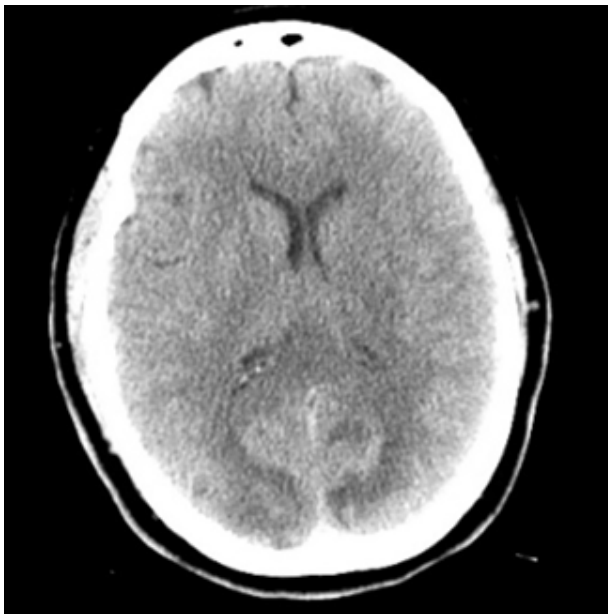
The axial CT of the brain shows fairly symmetric subcortical hypodensity involving a posterior predominant pattern highly suspicious for PRES.
